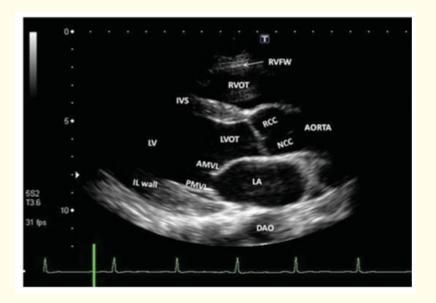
Left parasternal window long axis view.
